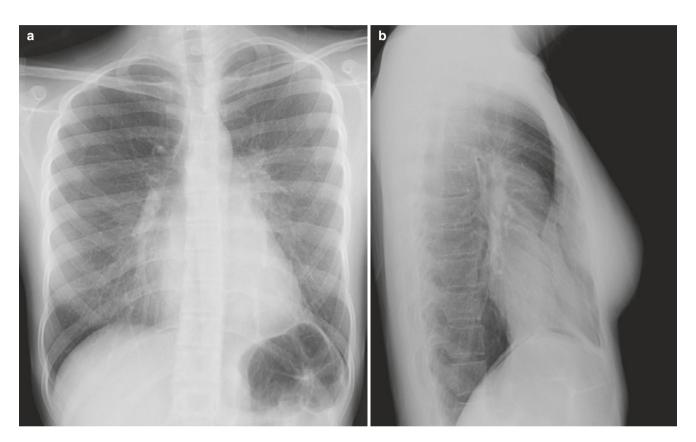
Pectus excavatum. (a, b) Frontal radiograph showing blurring of the right heart border mimicking the right middle lobe pathology, horizontal posterior ribs, and vertical anterior ribs. (b) Lateral radiograph reveals depressed sternum
